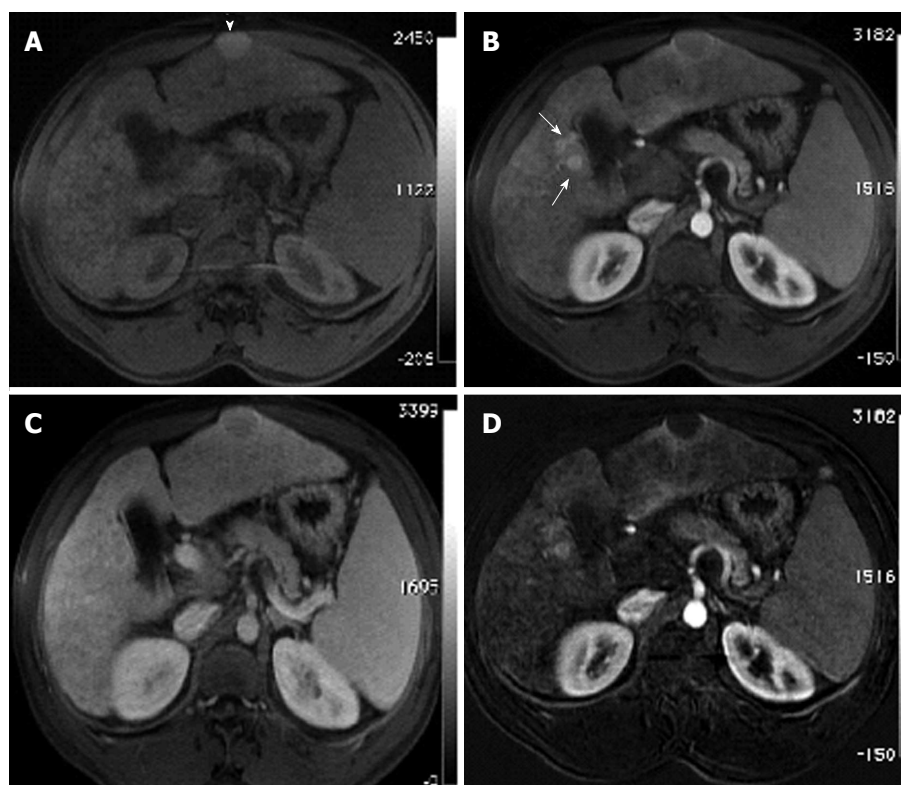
Incidentally discovered solitary left hepatic lobe nodule on screening ultrasound, referred as suspicious nodule for HCC, for MRI evaluation. A: Pre- and post-contrast fat-suppressed 3D-GRE T1-weighted images during the (B) late hepatic arterial and (C) delayed phases; D: Post-processed subtracted arterial image. The known left hepatic lobe nodule demonstrate increased intrinsic T1 signal (arrowhead, A), without appreciable increased arterial enhancement (B), confirmed on subtraction images (D), in keeping with a macro-regenerative nodule. However, the MRI reveals multiple small foci at hepatic segment #5 that show increased arterial enhancement (arrows, B) and delayed washout (D) in keeping with multiple small HCCs. HCC: Hepatocellular carcinoma; MRI: Magnetic resonance imaging; GRE: Gradient recalled echo.
